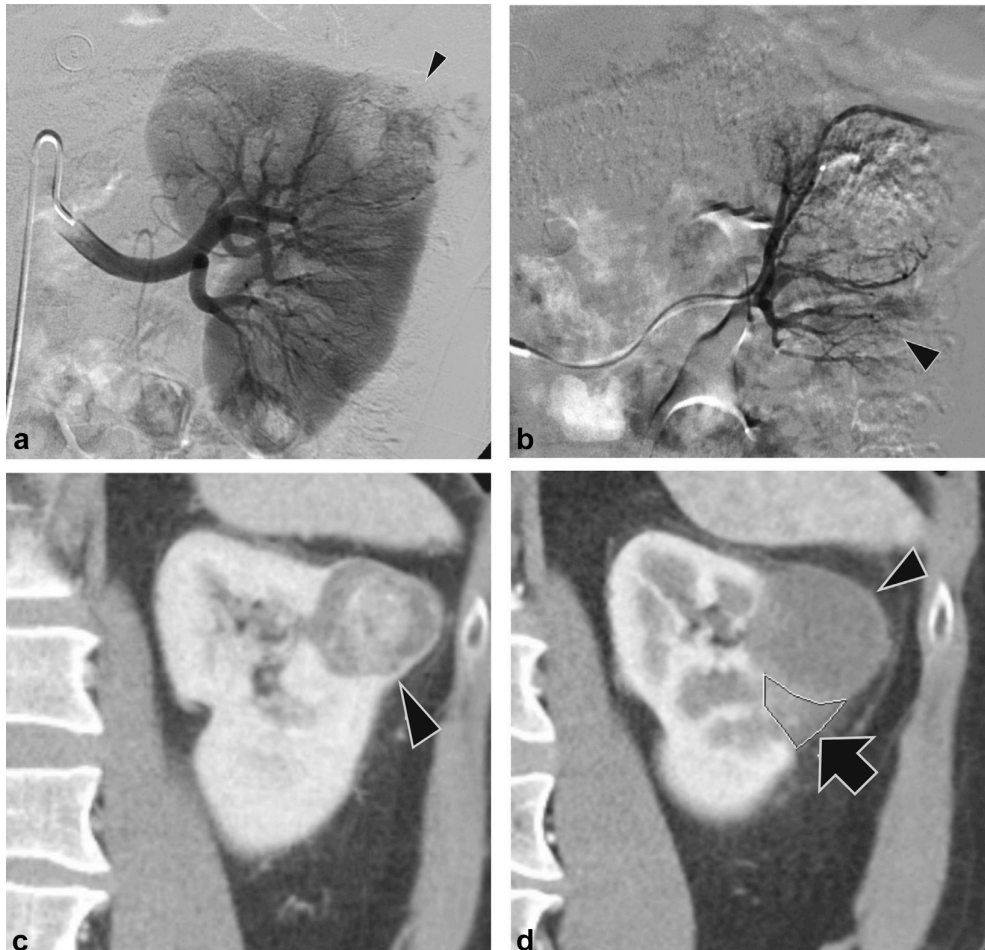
Images of RCC treated by TACE in patient 12. (a) Subtraction angiography image obtained after selective catheterization of the left renal artery showed contrast-filled intratumoral vessels (arrowhead) before TACE. (b) Subtraction angiography image obtained during TACE showed no contrast-filled vessels in the center of the tumor owing to ongoing embolization. The area adjacent to the RCC (arrowhead) shares its blood supply with the tumor. (c) CT image obtained before TACE showed contrast enhancement in the RCC (arrowhead). (d) CT image obtained 4 weeks after TACE showed no contrast enhancement in the RCC (arrowhead). Infarcted renal tissue (arrow) is adjacent to the treated tumor.
